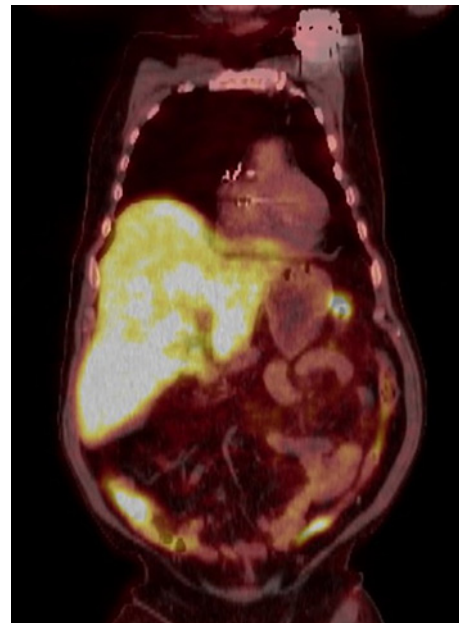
PET/CT scan at the time of the TLS, showing hepatomegaly and diffuse metabolic activity in the liver, consistent with active metastatic disease. PET, positron emission tomography.
